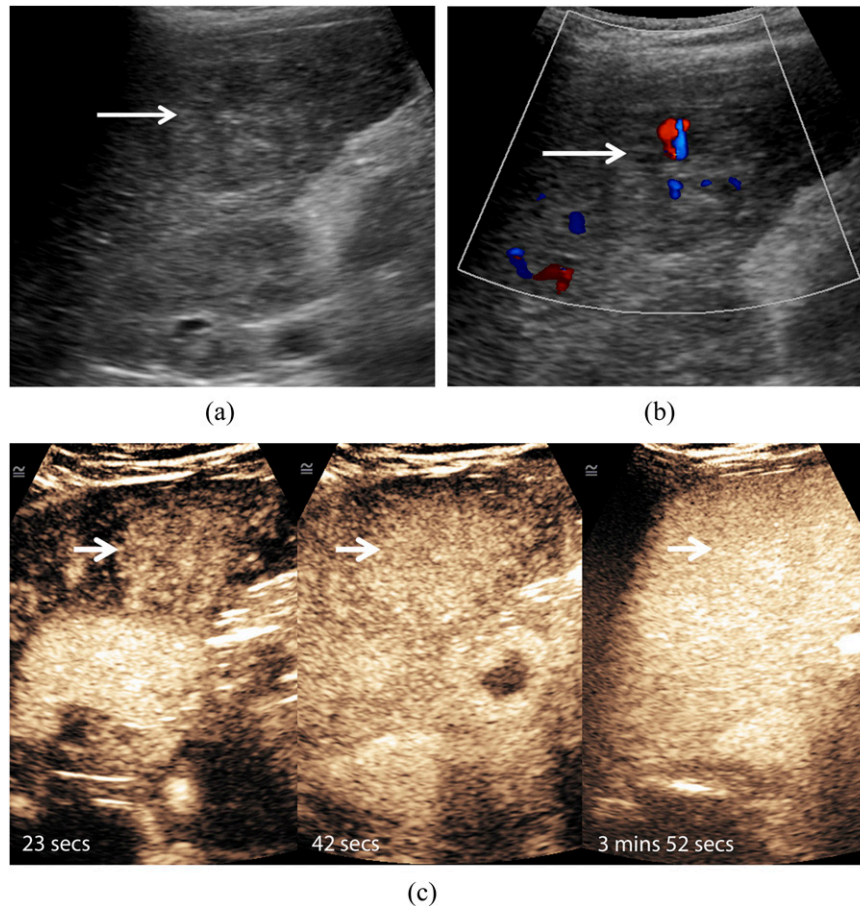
A 12-year-old male diagnosed with focal nodular hyperplasia (FNH): B-mode ultrasonography (a) has identified a heterogeneous ill-defined focal liver lesion (arrow). Colour Doppler technique (b) is revealing the presence of blood vessels in the central part of the lesion (arrow). Following the administration of 2.4 ml of SonoVue™ (Bracco SpA, Milan, Italy), contrast-enhanced ultrasound (c) is demonstrating a centrifugal pattern of enhancement of the lesion (arrows) and no washout in the late phase, establishing the diagnosis of an FNH.
